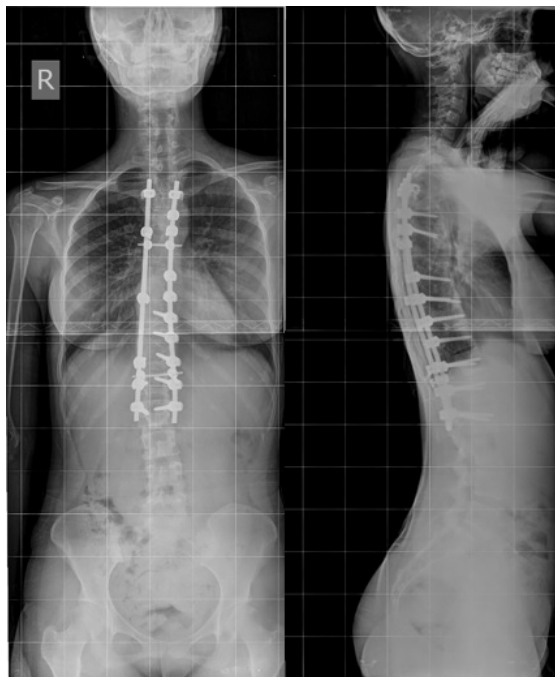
Postoperative anteroposterior and lateral x-rays of an AIS patient with eleven thoracic vertebrae.
